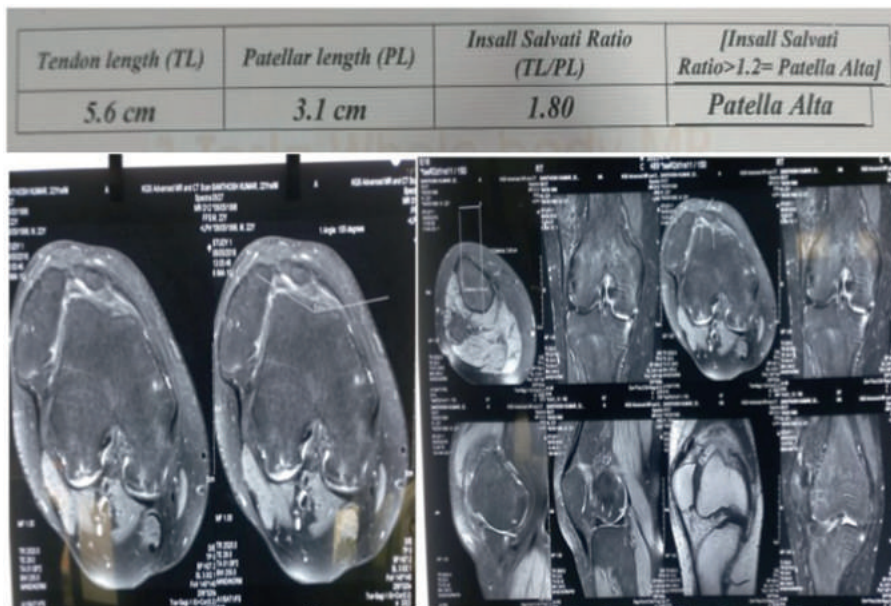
MRI findings depicting the pathoanatomy with altered indices.
